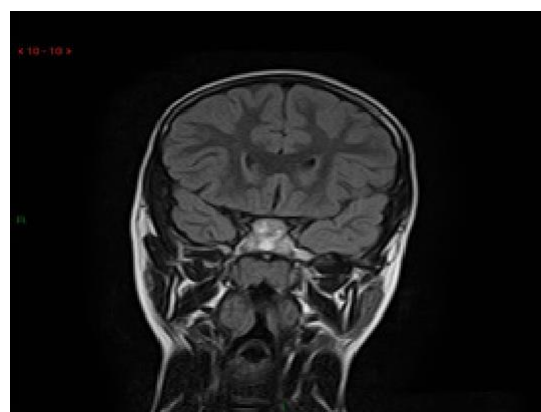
Coronal T2 MRI brain.
